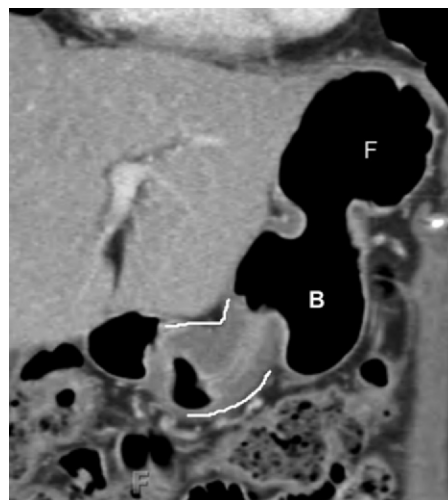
Gastric anatomy. Coronal CT image of the stomach with intravenous contrast material in an asymptomatic patient demonstrates gaseous distention of the gastric fundus (F) and body (B) with peristalsis of the antrum, resulting in apparent antral thickening (bounded by white lines). There are no ancillary findings to suggest gastritis.
